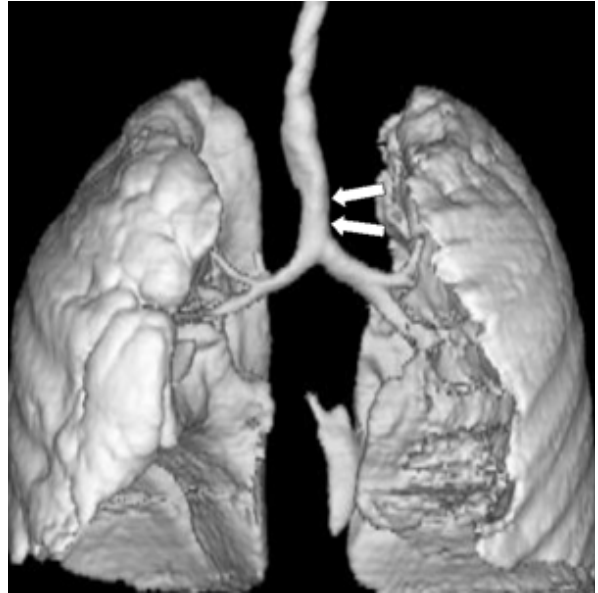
Three-dimensional reconstruction CT image obtained 12 months after stent removal, anteroposterior view, shows a widened lumen (arrows) of the lower trachea. The diameter of the dilated lumen is 7 mm.
